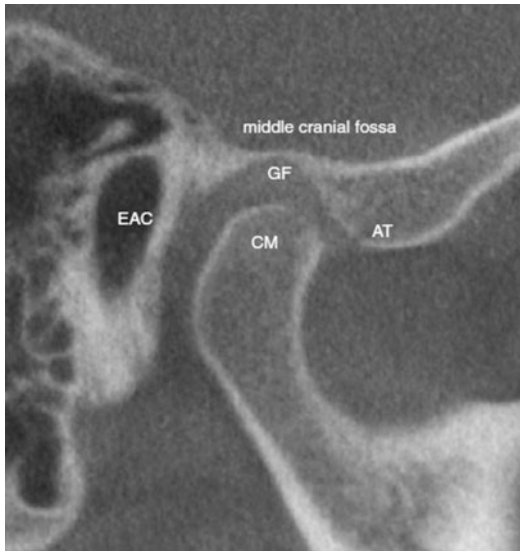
Radiographic image shows the close proximity of the condylar head to the middle cranial fossa and external auditory canal. *CM* condylar mass, *GF* glenoid fossa, *AT* articular tubercle, *EAC* external auditory canal. (Reprinted/adapted by permission from T. von Arx, S. Lozanoff, *Clinical Oral Anatomy*, DOI 10.1007/978-3-319-41993-0_25)
